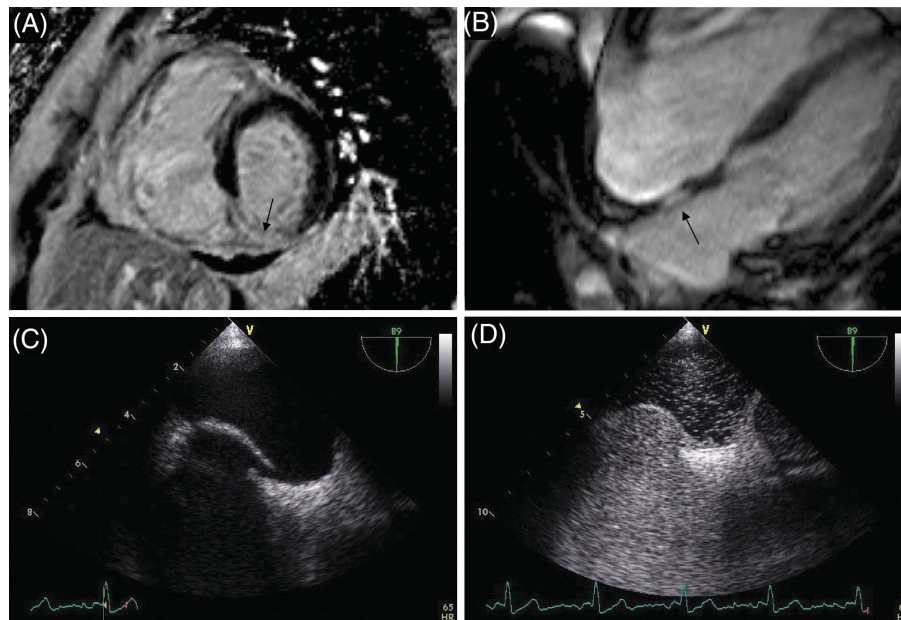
Myocardial infarction resulting from systemic embolism through a patent foramen ovale. (A and B) A gadolinium-enhanced short-axis view demonstrating transmural myocardial infarction (arrows). Cine imaging in the horizontal long axis (HLA) view shows a suspected patent foramen ovale in the inter-atrial septum (arrow), which is confirmed on bubble-contrast transoesophageal echocardiography (C and D).
